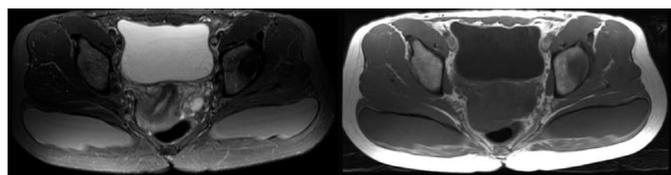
Normal appearance of magnetic resonance imaging of intramuscular implants. (a) Axial T2 with fat saturation; (b) Axial T1. Intermediate silicon signal in both sequences.
